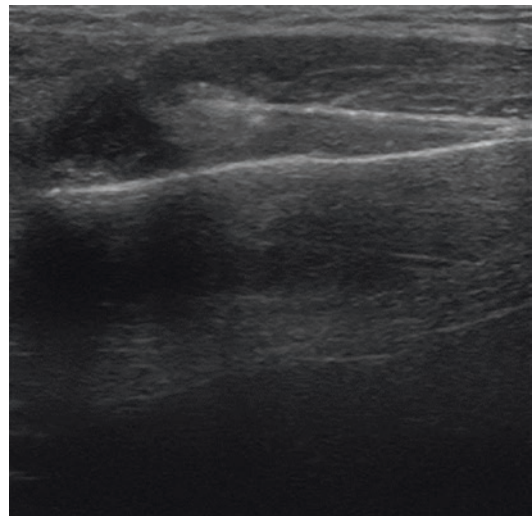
Ultrasound image of masseter RFA. The top line is the RFA probe and the lower line delineates the mandible
